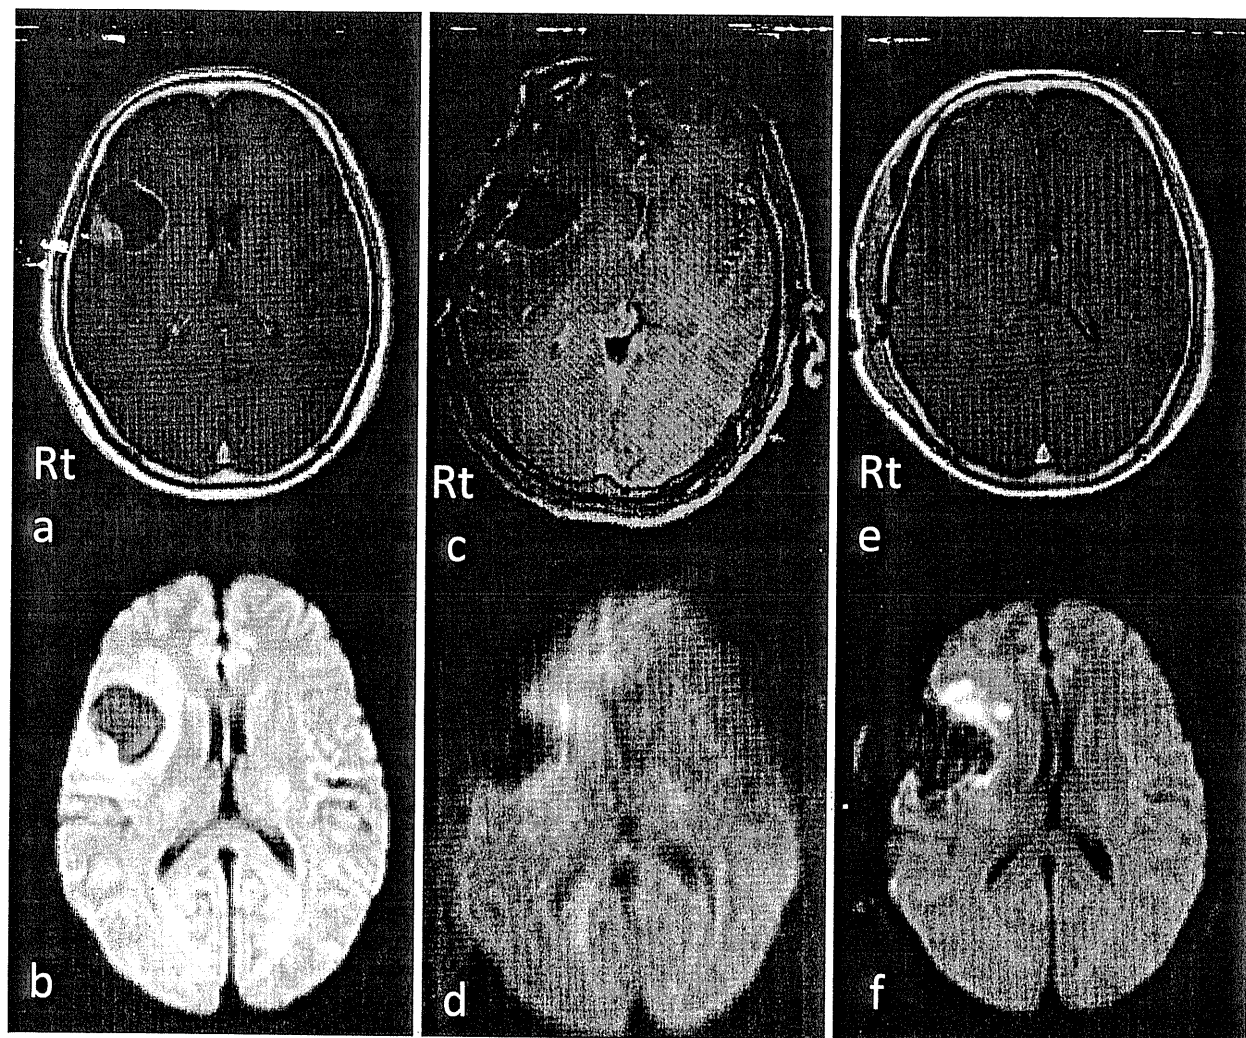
Post-operative DW image revealed high signal area adjacent to the resection cavity (e, f). Intraoperative MR images do not show the abnormal intensity area (c, d). Preoperative MR images (a, b).
